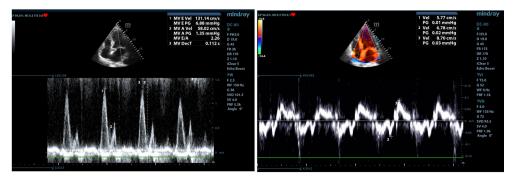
a.3. Type 3 (restrictive pattern) of a diastolic dysfunction with increased E velocity of 131 cm/s, E/A ratio=2.26 and E/e's=22.7 (left: transmitral diastolic flow-PW Doppler; right: septal tissue Doppler, 4-chambers view)
